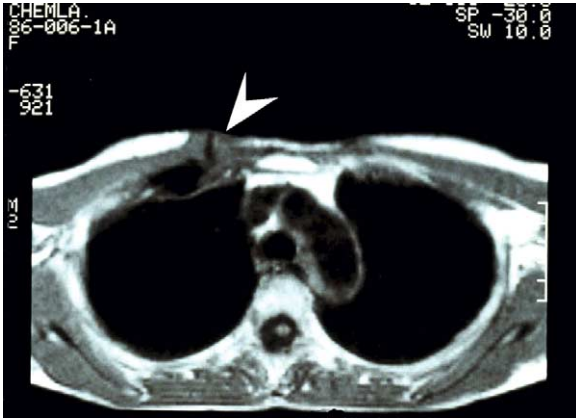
MRI, 1.5 T, T2-weighted images of the woman described in Fig. 1(A). The right chest wall exhibits a large area of costal and muscular radionecrosis (arrow) and a fistulous track is visible in the right part of the sternum (arrow).
